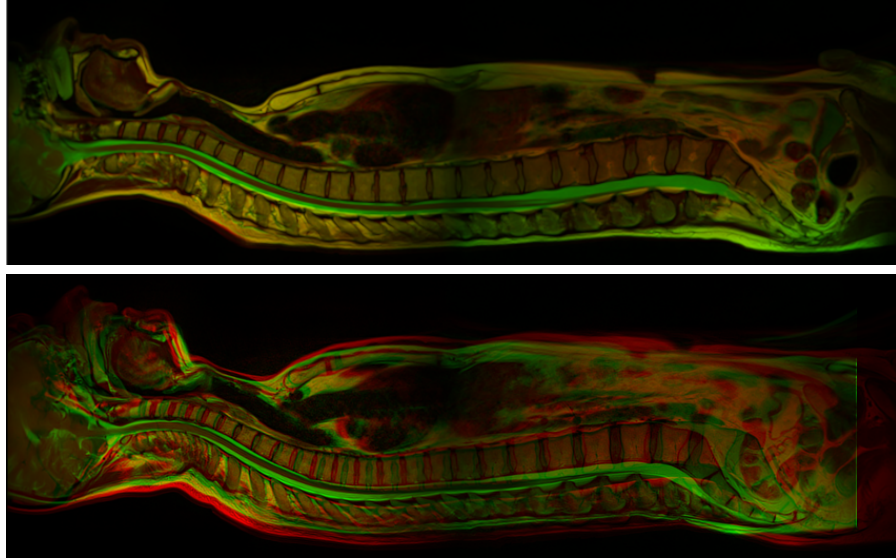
Aligned (top) and misaligned (bottom) T1- and T2-weighted records. Red channel: T1, green channel: T2
